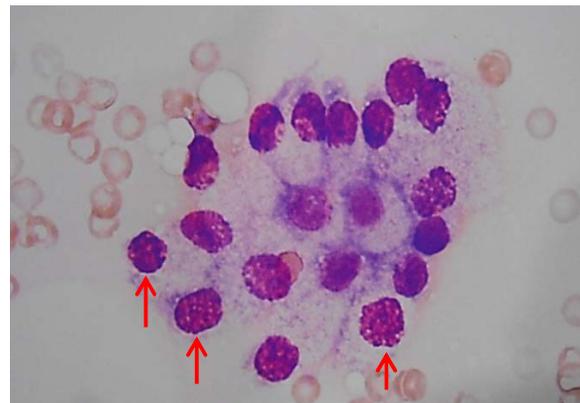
Cytology findings of uniform and well-differentiated epithelial cells (arrow) which was suggestive of hyperplasia from fluid aspirated by ultrasound-guided fine needle aspiration.
